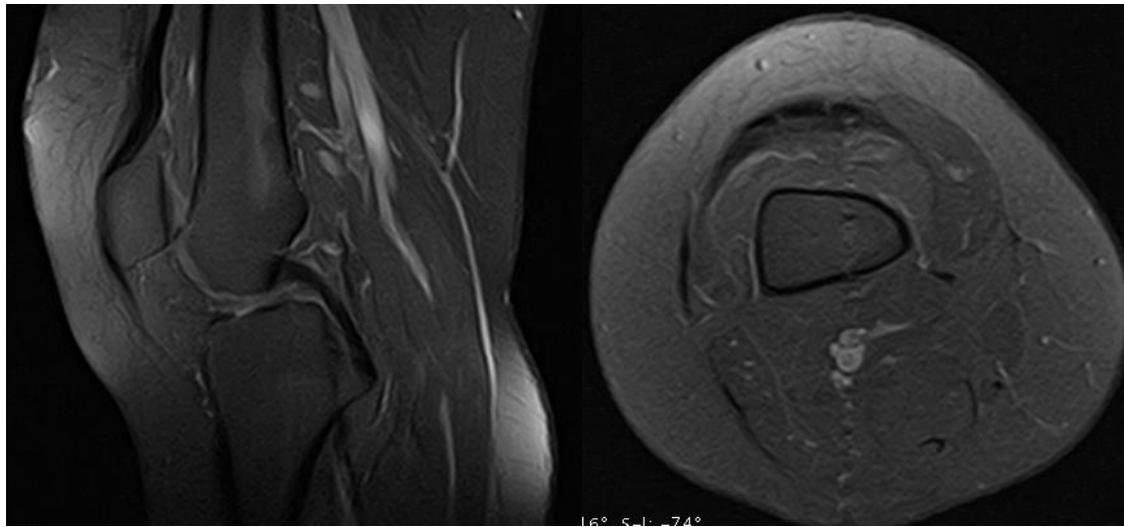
A T2 weighted saggital and axial view MRI of the left knee post anti-tuberculosis treatment
